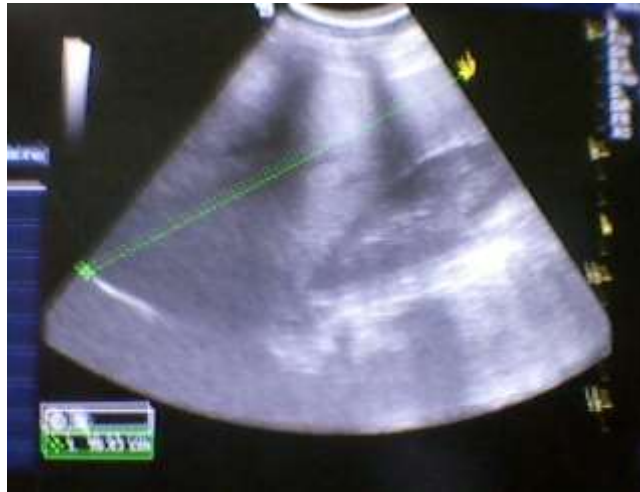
Longitudinal ultrasound image of the liver demonstrating increased liver echogenicity and hepatomegaly in a 43 year old female HIV positive patient.
